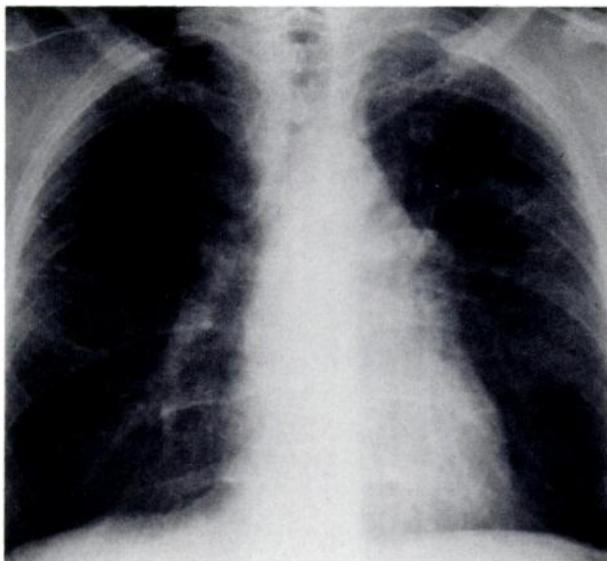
Chest radiograph of September 14, 1987, after three months of corticosteroid therapy, demonstrates marked reduction in nodule size and profusion as well as clearing of the basal alveolar infiltrate.
